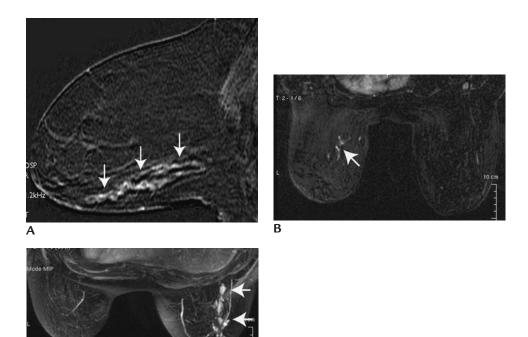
DCIS. (A) MRI, sagittal subtraction image demonstrating linear, clumped enhancement (*arrows*) characteristic of DCIS. (B) Different patient. Axial subtraction image demonstrating linear clumped enhancement (*arrow*) centrally in the left breast corresponding to a site of DCIS. (C) Different patient. Maximum intensity projection (MIP). Demonstrating a 7-cm area of linear clumped and stippled enhancement (*arrows*) laterally in the right breast. In this patient, a 1-cm cluster of calcifications was identified posteriorly on the mammogram (not shown). The true extent (7 cm) of the disease (confirmed pathologically) was shown on the MRI.
